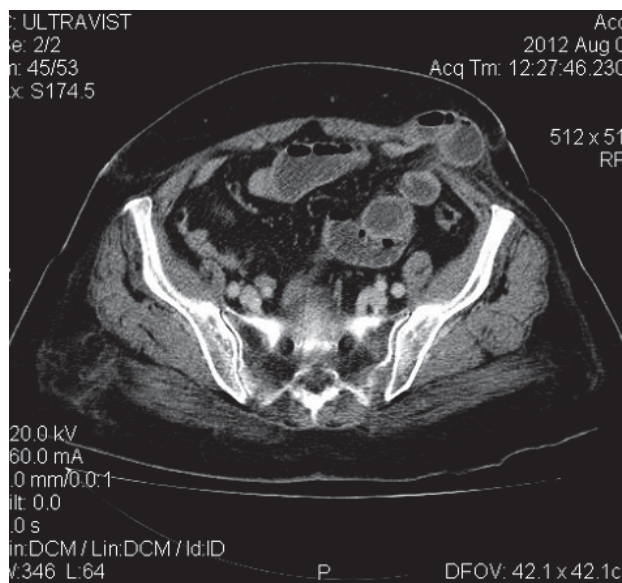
Multislice computed tomography image of the abdomen shows a herniated loop of the small bowel in the left lateral abdominal wall.
